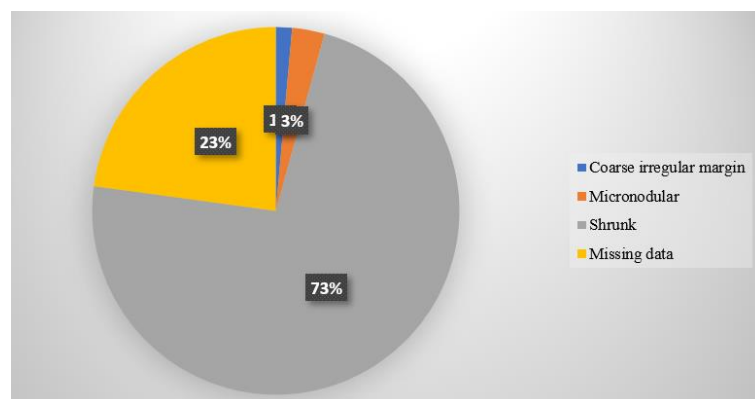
Ultrasound Features of Liver Among Study Participants
